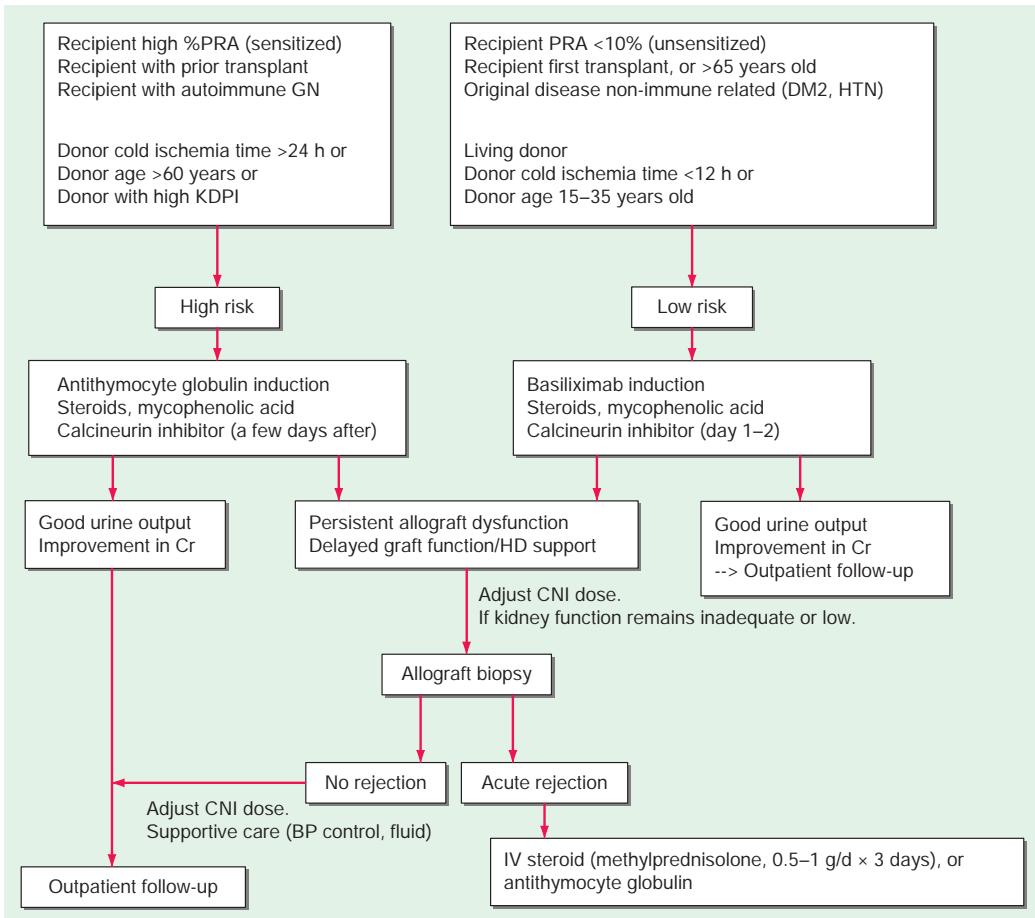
A typical algorithm for early posttransplant care of a kidney recipient. If any of the recipient or donor "high-risk" factors exist, more aggressive management is called for. Low-risk patients can be treated with a standard immunosuppressive regimen with no or less-potent induction therapy (e.g., basiliximab). Patients at higher risk of rejection or early ischemic transplant dysfunction are often induced with an antithymocyte globulin to provide more potent early immunosuppression or to spare calcineurin use in the immediate posttransplant period. *When there is early transplant dysfunction, prerenal, obstructive, and vascular causes must be ruled out by ultrasonographic examination. The panel reactive antibody (PRA) is a quantitation of how much antibody is present in a candidate against a panel of cells representing the distribution of antigens in the donor pool. BP, blood pressure; CNI, calcineurin inhibitor; Cr, creatinine; DM2, type 2 diabetes; GN, glomerulonephritis; HD, hemodialysis; HTN, hypertension; KDPI, Kidney Donor Profile Index.
